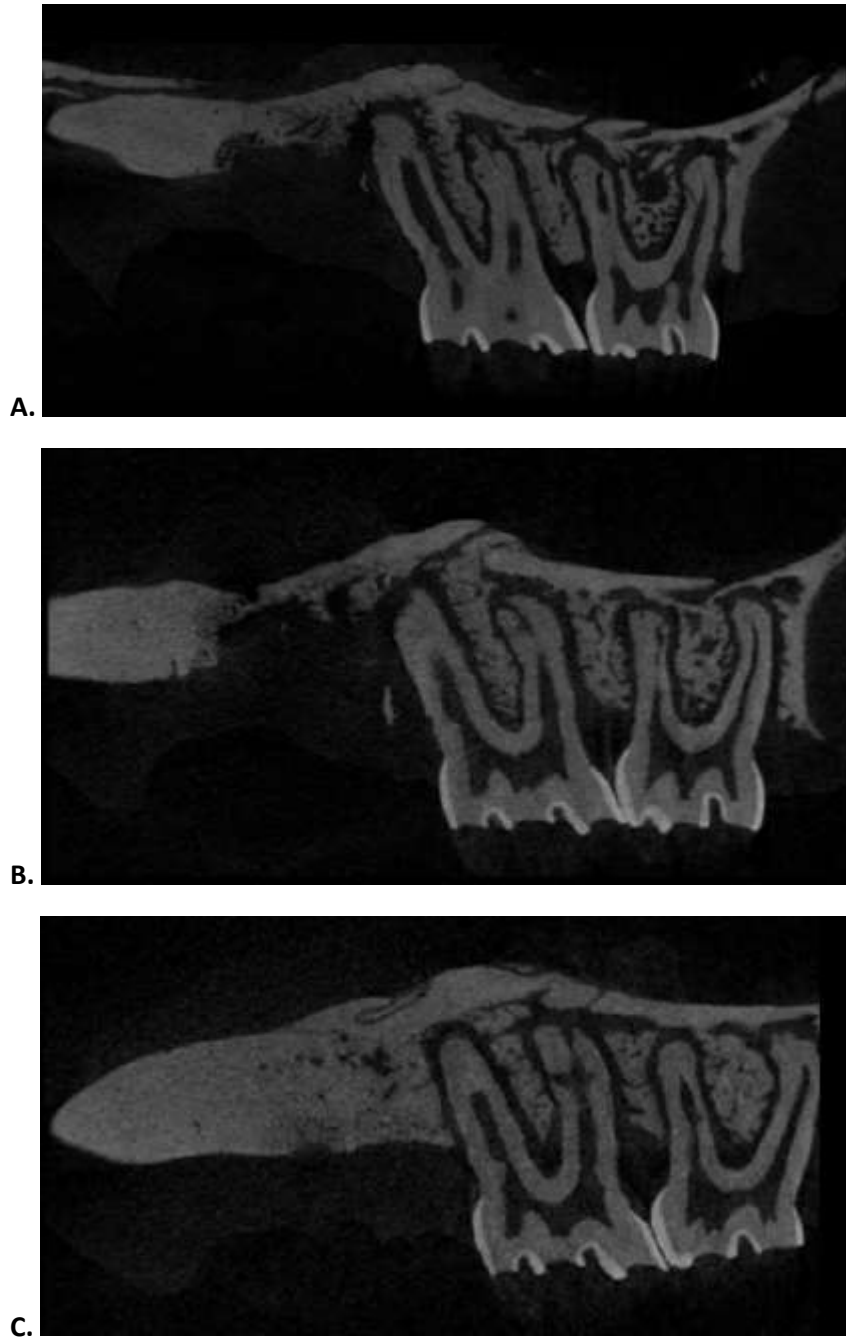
Representative μ CT for interproximal bone changes from Part 2.
